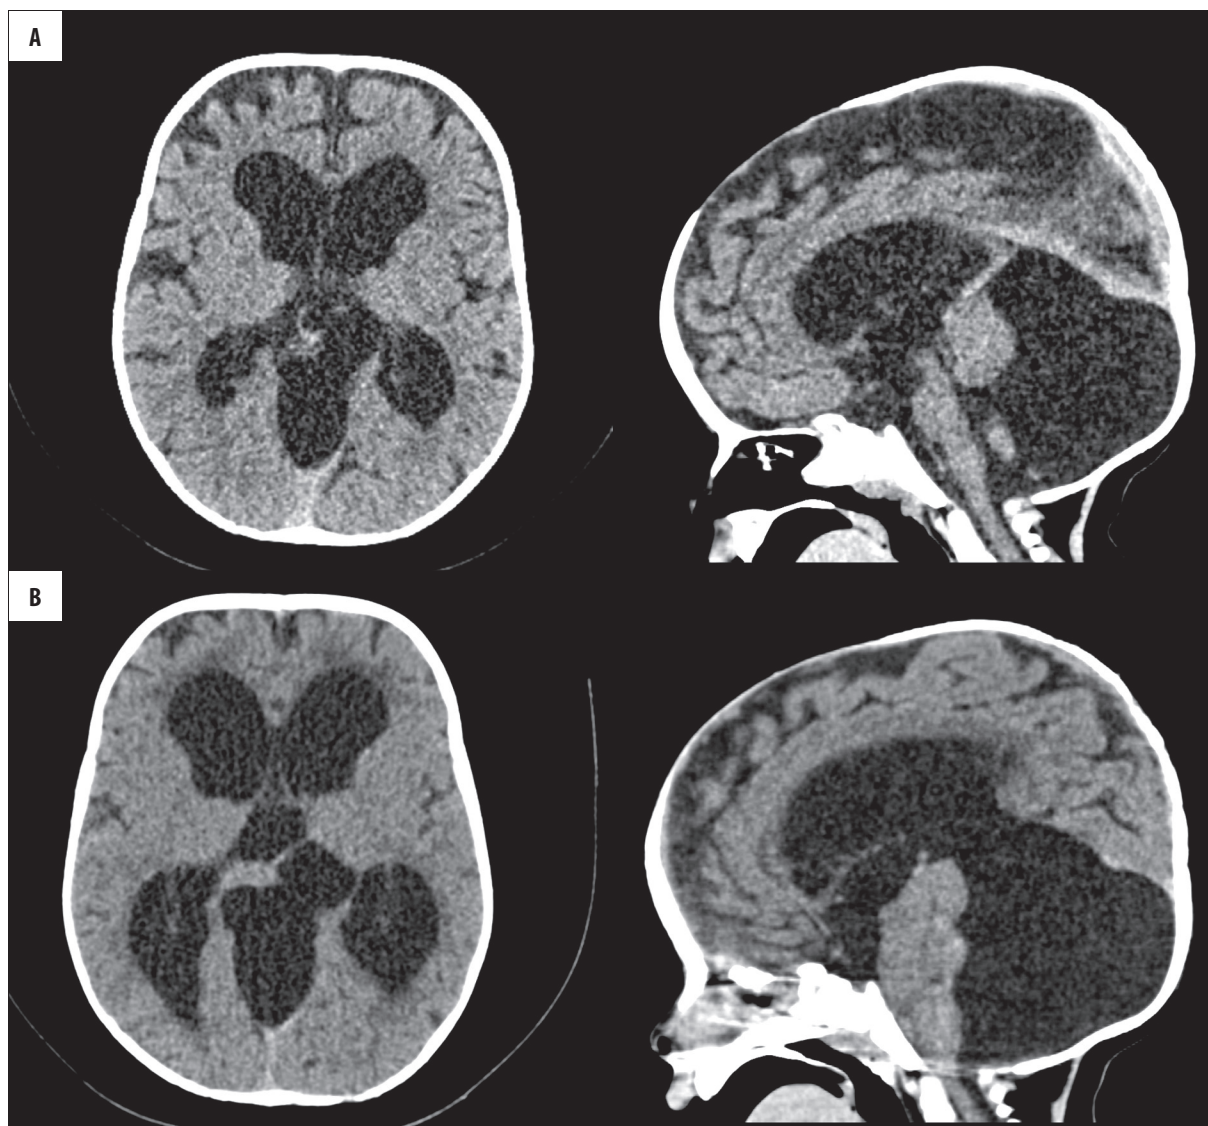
Nonenhanced computed tomography, axial and sagittal brain CT. (A) image in the low-dose protocol, (B) image in the standard protocol.
